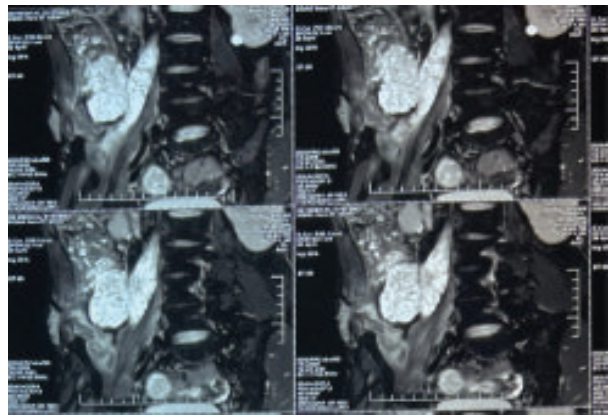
MRI scans showing large right iliopsoas abscess.
